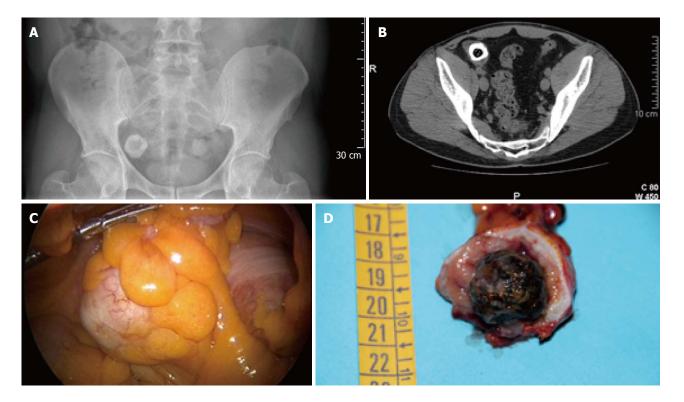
Abdominal pain. A: Lower abdomen X-ray shows a rounded radio-opaque formation in the right iliac fossa; B: Lower abdomen computed tomography showing a roundish-filling defect in right iliac fossa; C: Laparoscopic intraoperative view of the dilated appendix due to the presence of a foreign body; D: The marrow-bone included in a calcified fecaloma.
